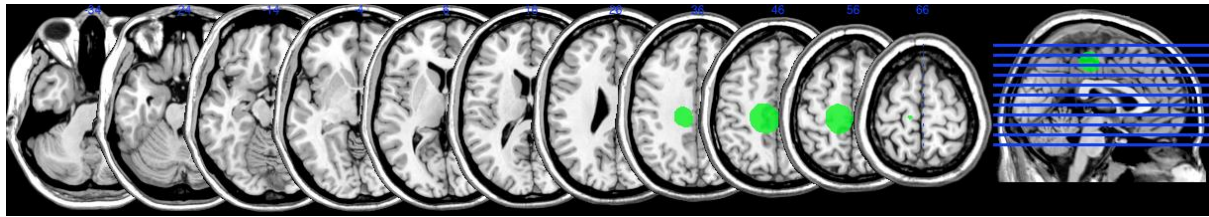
MRI scan of patient RF
